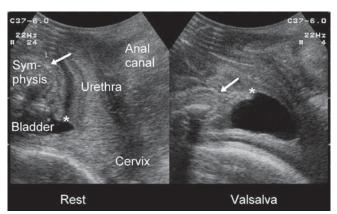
Pelvic floor Ultrasound, midsagittal plane. The image on the left is taken at rest, the one on the right is on maximal Valsalva.
